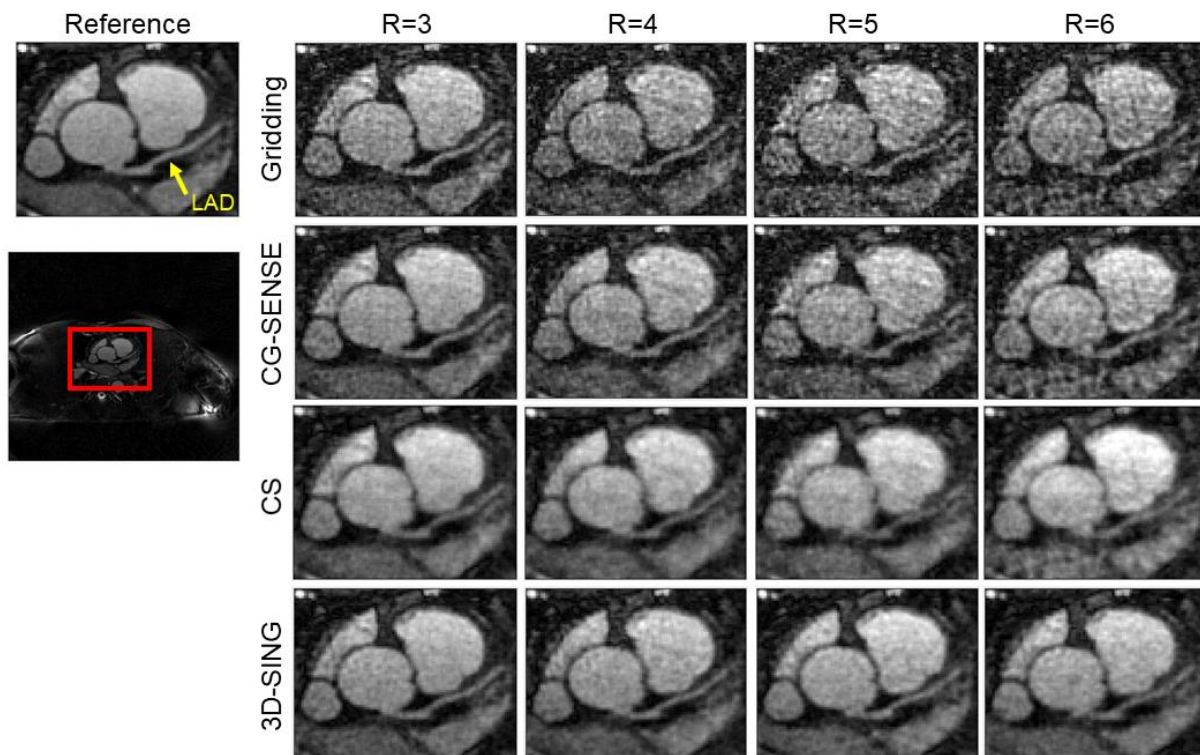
The cropped axial slices from a 3D coronary MRI dataset reconstructed with gridding, CG-SENSE, CS, and 3D-SING at retrospective rates of 3, 4, 5, and 6. The reference image, gridding reconstruction of all projections, is shown in the left column for the gridded FOV of  $(440\text{mm})^3$  from the data acquired with a nominal  $(220\text{mm})^3$  FOV. The cropped region has a FOV of  $80 \times 103\text{mm}^2$ . LAD=Left Anterior Descending artery.
